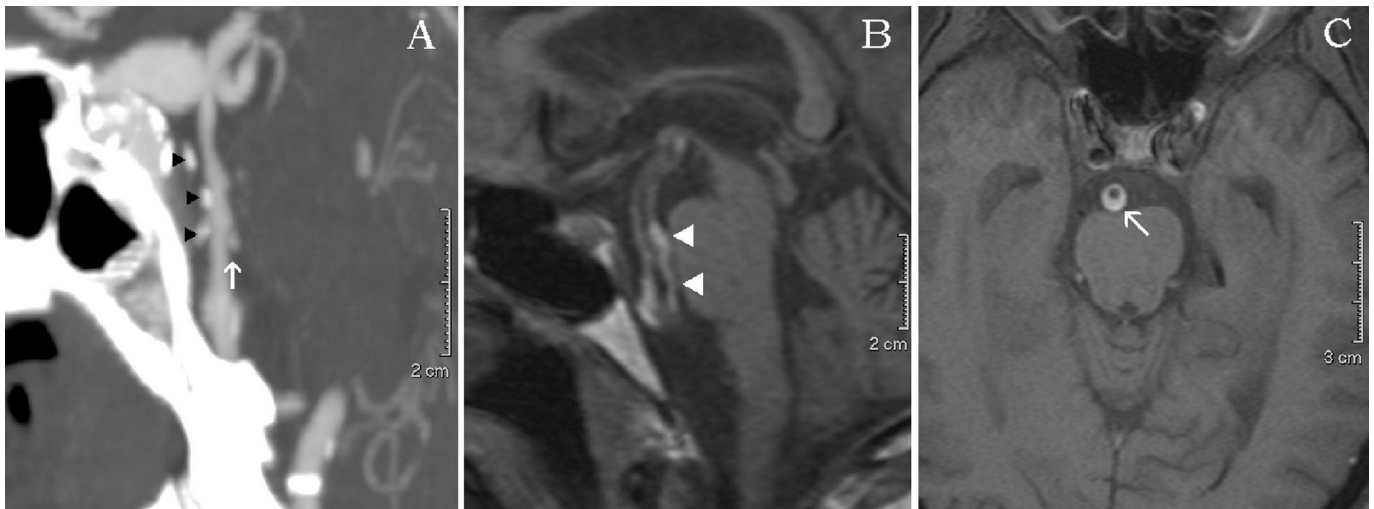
Sagittal computed tomographic angiography image depicts basilar artery (A) with atheroma (arrowhead) and proximal segment of dissection (arrow). T1-weighted images reveal clot in the atheromata (arrowheads, B) and T1 fat-suppressed image depicts circumferential clot in the vessel wall (arrow, C).
